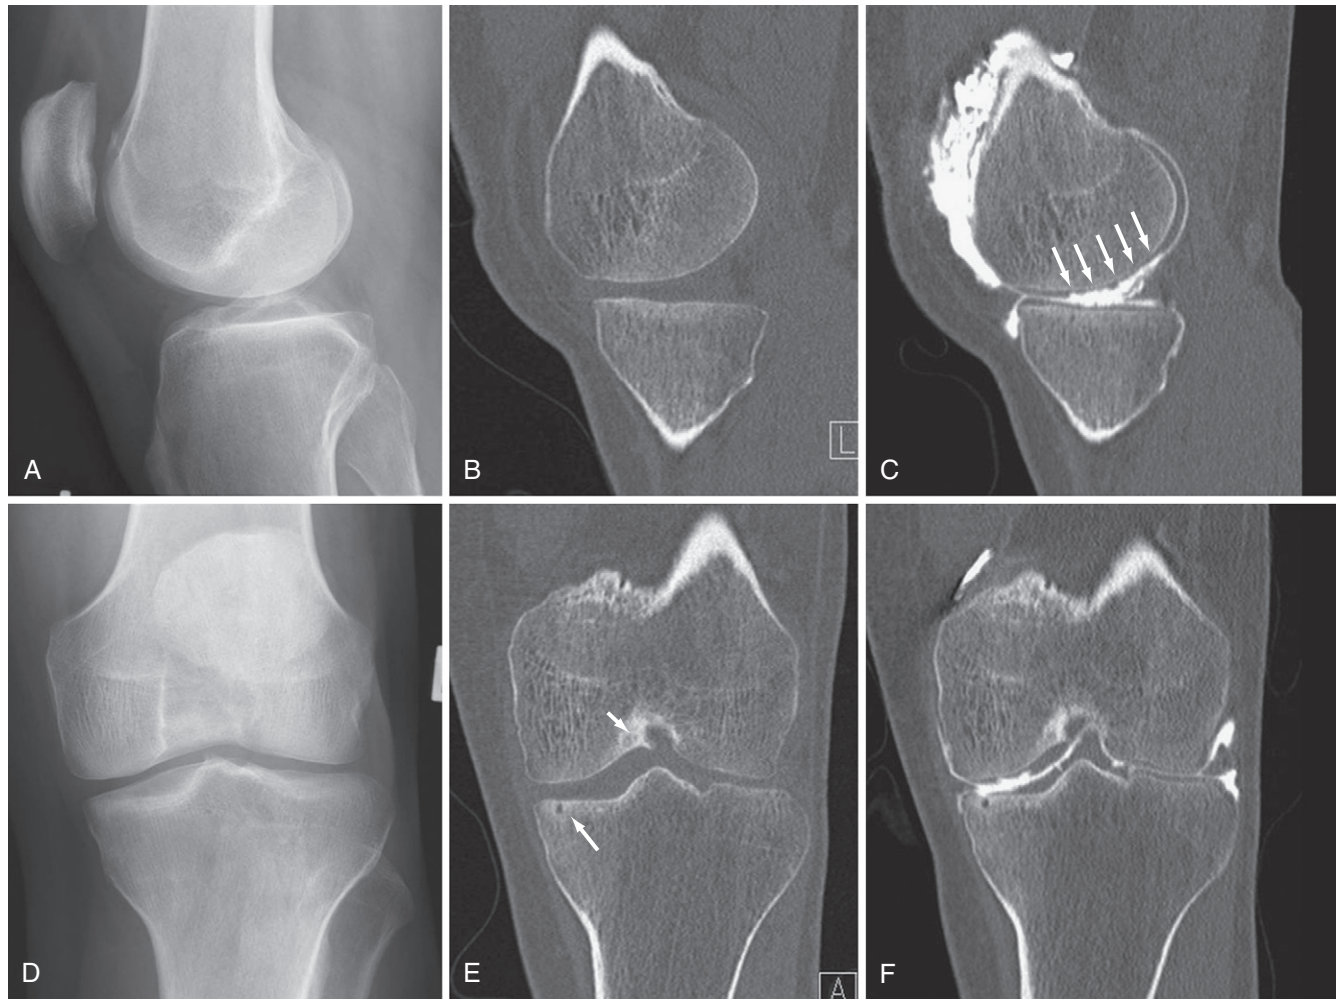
X-ray, computed tomography (CT), and CT arthrogram of the knee of in a 46-year-old male patient with unexplained pain and locking. Initial x-rays (A and D) appear near normal with preserved joint space, a tiny osteophyte arising from the medial tibial spine, and no other definite abnormality. CT scan with sagittal (B) and coronal (E) reconstructions confirms the presence of osteophytosis (*short arrow*) and a small subchondral cyst (*long arrow*) but show no definite chondral changes. CT arthrogram with sagittal reconstruction (C) demonstrates several focal hyaline cartilage thinning (*arrows*) and a meniscal tear. On the coronal reconstruction (F), the tibial subchondral cyst is associated with complete loss of overlying hyaline cartilage.
